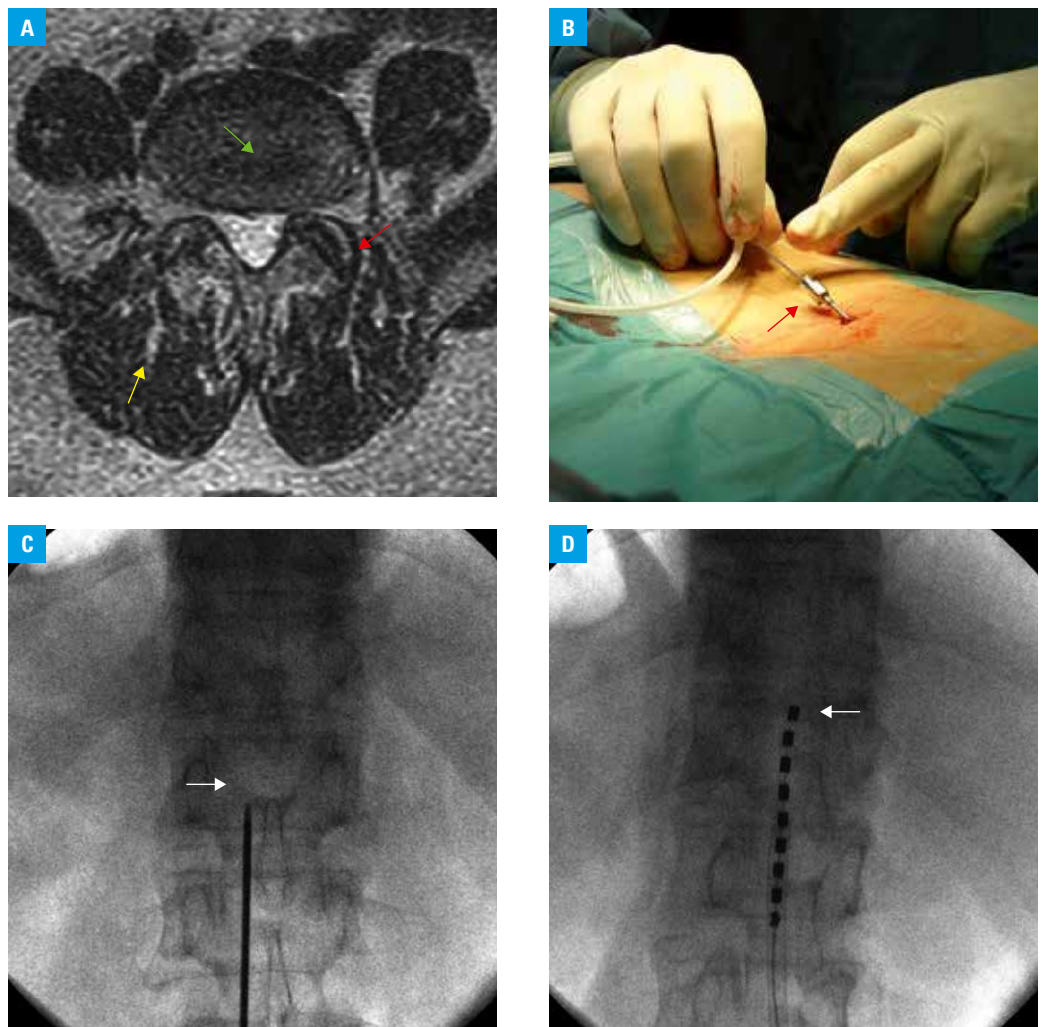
Magnetic resonance imaging of the lumbar spine and spinal cord stimulation procedure; A – axial plane magnetic resonance imaging (MRI) at the L4/L5 level. Lumbar spine spondylosis pertains to degeneration of the facet joints (red arrow), dehydration of discs (green arrow), and occurrence of fat tissue in the paravertebral muscles (yellow arrow); based on the symptoms and MRI findings, the patient was not offered any spinal decompression surgery; B – the prone position enables the insertion of the Touhy needle (red arrow) to the epidural space at the level below Th12 for guidewire placement; the whole procedure is conducted under local anesthesia; C – AP intraoperative radiogram visualizing the entry point for the Touhy needle tip to the epidural space (white arrow); D – percutaneous stimulating lead (S8, St. Jude Medical Company, Minneapolis, Minnesota, United States) is inserted through introduction sheath system (Epiducer, St. Jude Medical Company); the tip of the electrode is steerable by a curved stylet (white arrow), which allows for the placement at the desired vertebral level
